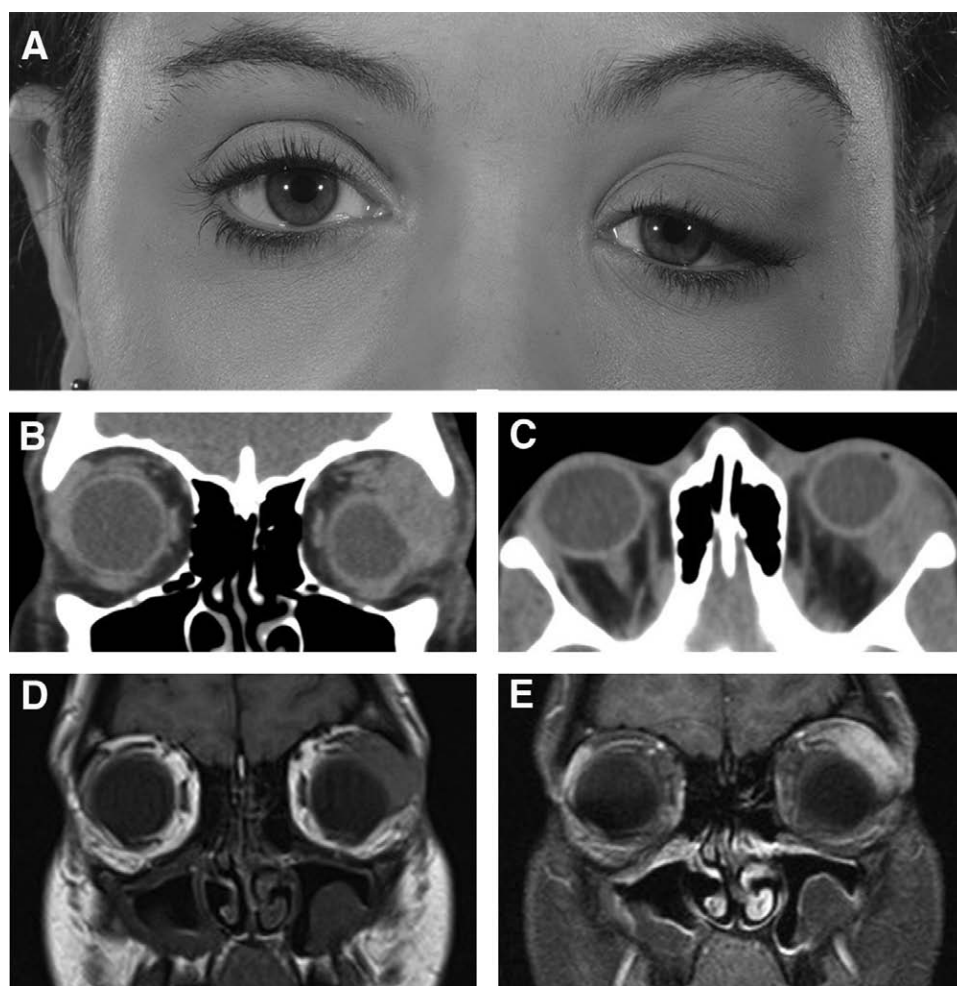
Case 1. Unilateral sclerosing dacryoadenitis. A, A 27-year-old female, otherwise well, presented with 4 weeks increasing left upper eyelid swelling with mild ache, and a hard tender mass in the left lacrimal gland. B and C, CT scans show a grossly enlarged lacrimal gland with flattening of the globe. D and E, MRI shows a discrete lacrimal gland lesion, which enhances with gadolinium. CT chest, abdomen, and pelvis were normal. She responded well to a course of oral steroids but was lost to follow up after 6 months.
